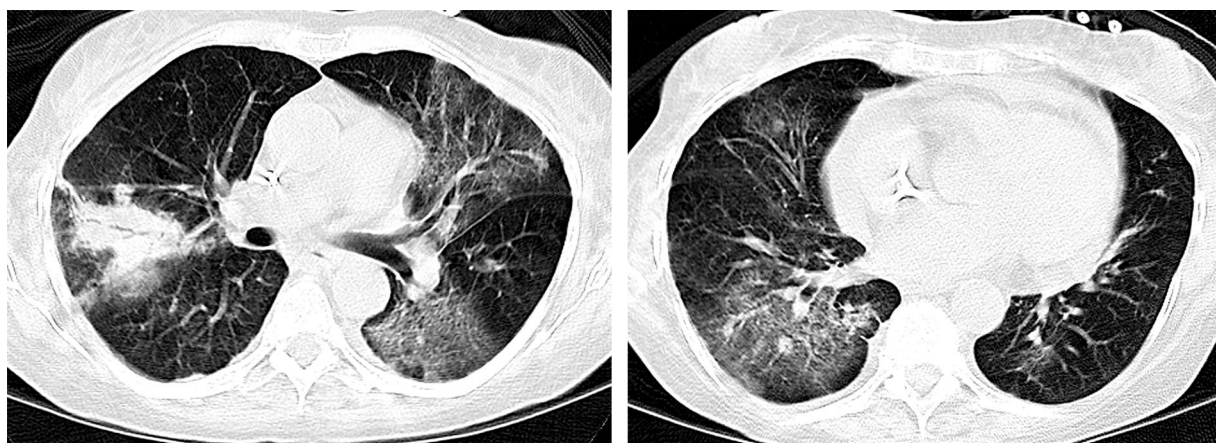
Zygomycetes* pneumonia following stem cell transplantation. CT scans obtained in two different patients show patchy consolidation (a) and ground-glass attenuation and nodules (b).
